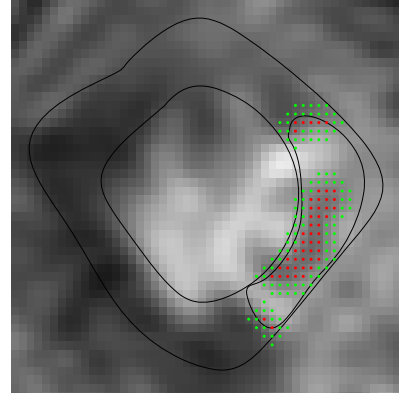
Original infarcted MRI with myocardium and scar manually delineated. Pixels in candidate MO-regions are shown in red while the added pixels resulting from dilation is shown in green.
